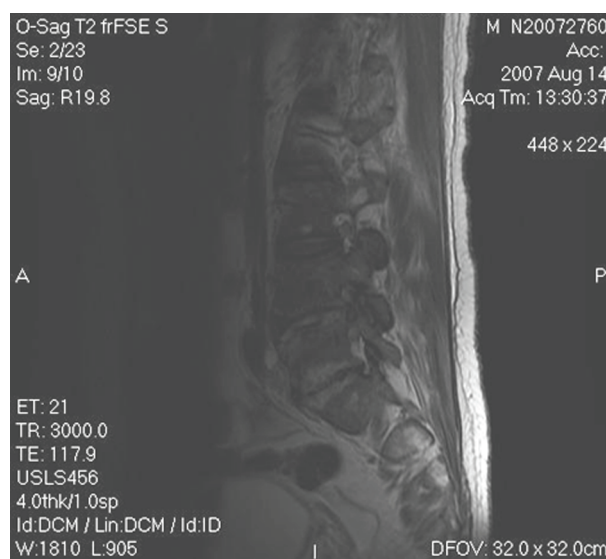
Lumbar-sacral column MRI.
